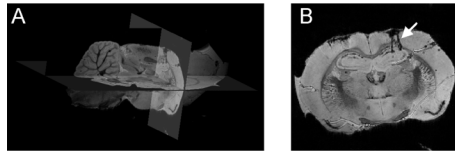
MR image of excised brain at 17.6 T. Part A is a view of three orthogonal slices through the 3-D MR image. Part B is the coronal slice, from the image in part A, showing the placement of two representative recording electrodes (indicated by the arrow).
